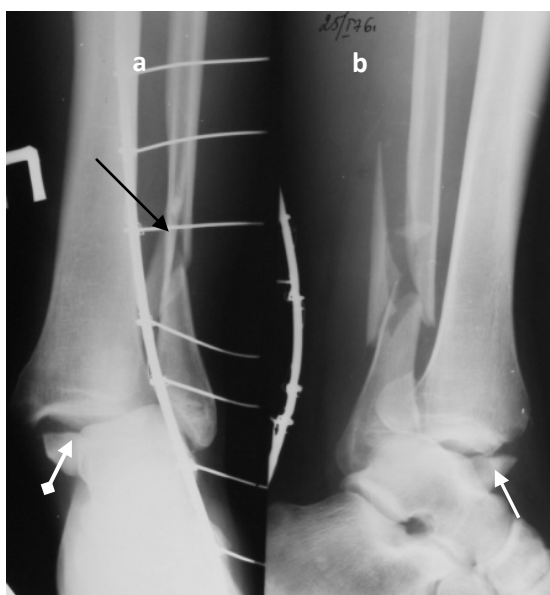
Radiographs of the shin in direct (a) and lateral (b) projections. A fracture line in distal third of diaphysis area of fibula with a bone splinter (a black arrow). The internal ankle-bone fracture line is located diametrically (a white arrow). Lateral subluxation of the foot (black diamond-shaped arrow). Fracture of the internal ankle-bone (intrajoint) and splintered fibula fracture with lateral subluxation of the foot
